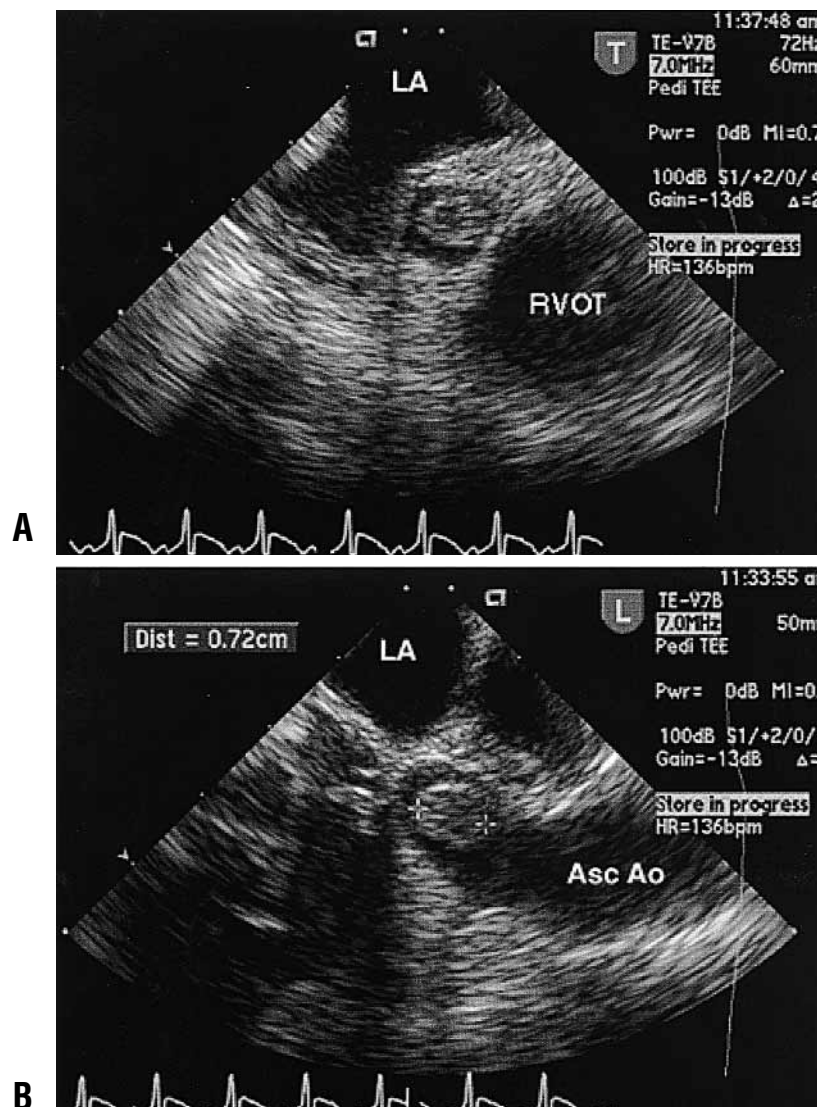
Transesophageal echocardiography images. A, Transverse plane at the base of the heart. The native proximal aortic root is seen in cross section immediately anterior to the left atrium. Thrombus occupies most of the lumen. The right ventricular outflow tract is anterior and to the left of the native aorta. B, Longitudinal plane. Proximal ascending aorta just above the aortic valve, heading cephalad. On echocardiographic imaging, the thrombus appeared sessile; thrombus movement was most likely restricted by the adjacent aortic walls. *LA*, Left atrium; *RVOT*, right ventricular outflow tract; *Asc Ao*, ascending aorta.
